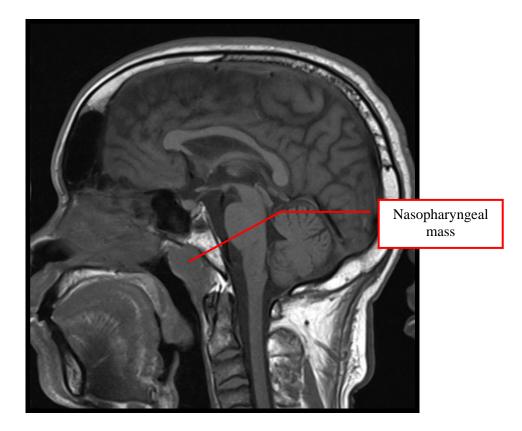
MRI sagittal section showing a mass in the nasopharynx.
